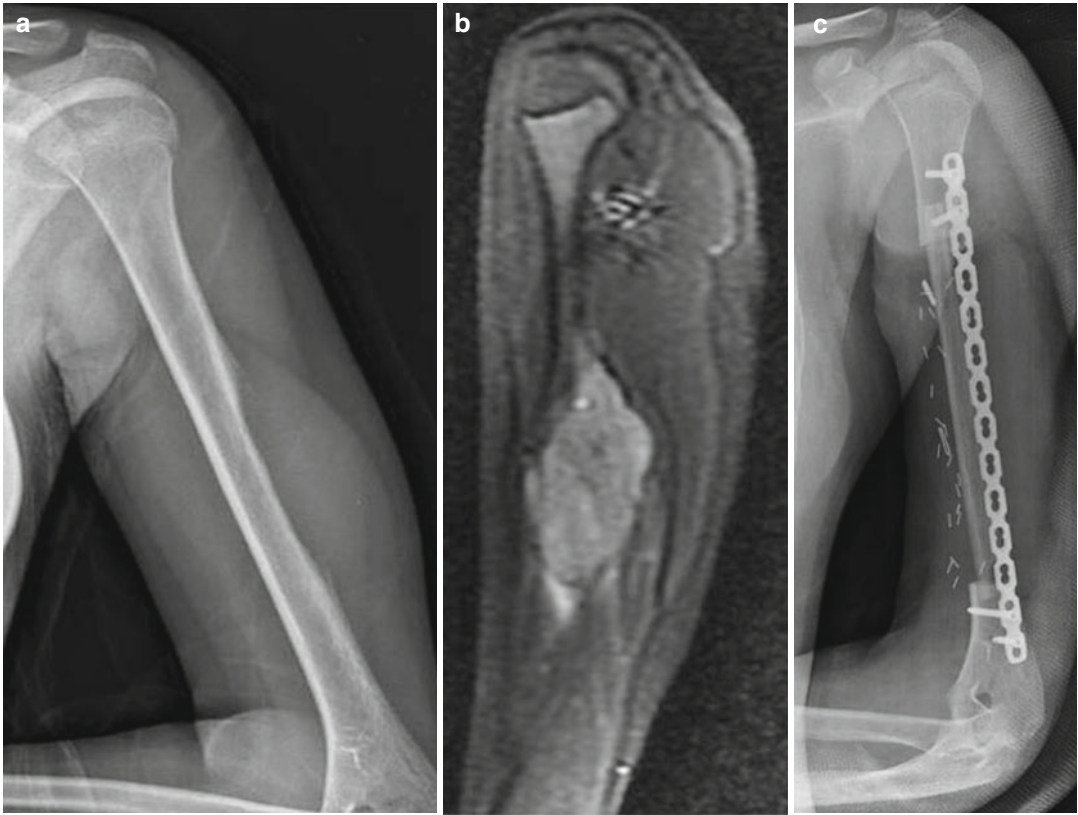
Ewing sarcoma. (a) Permeative destruction and periosteal reaction formed by a humeral diaphyseal lesion can be seen on conventional radiograph. (b) MRI is shows the intra/extracortical involvement of the tumor. (c)
